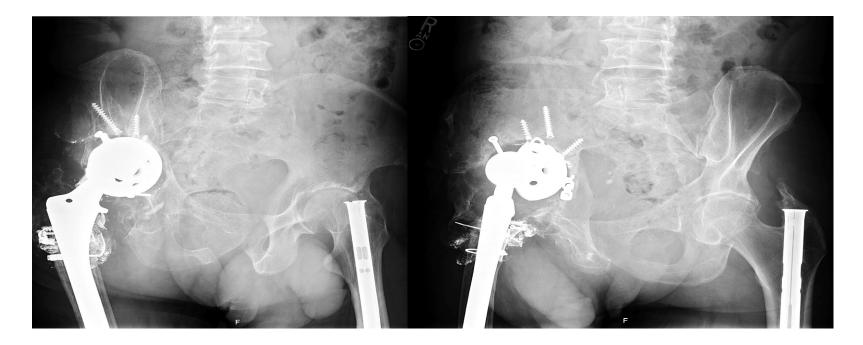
Preoperative Judet radiographs of the right hip showing acetabular and iliac bone loss with broken hardware and evidence of loose acetabular component.
